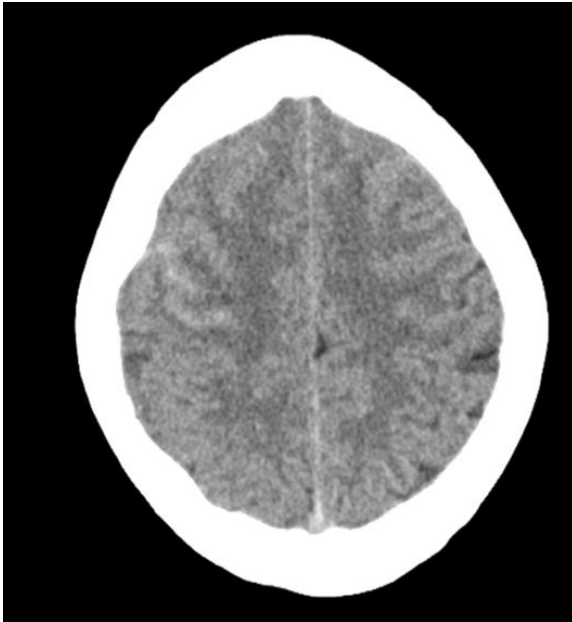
A CT of a 92-year-old patient presenting with confusion. There is a low density crescent shaped subdural collection on the right side suggesting subacute subdural haemorrhage. High density areas are seen posteriorly suggesting active bleeding giving the final diagnosis of acute on chronic subdural haemorrhage.*
